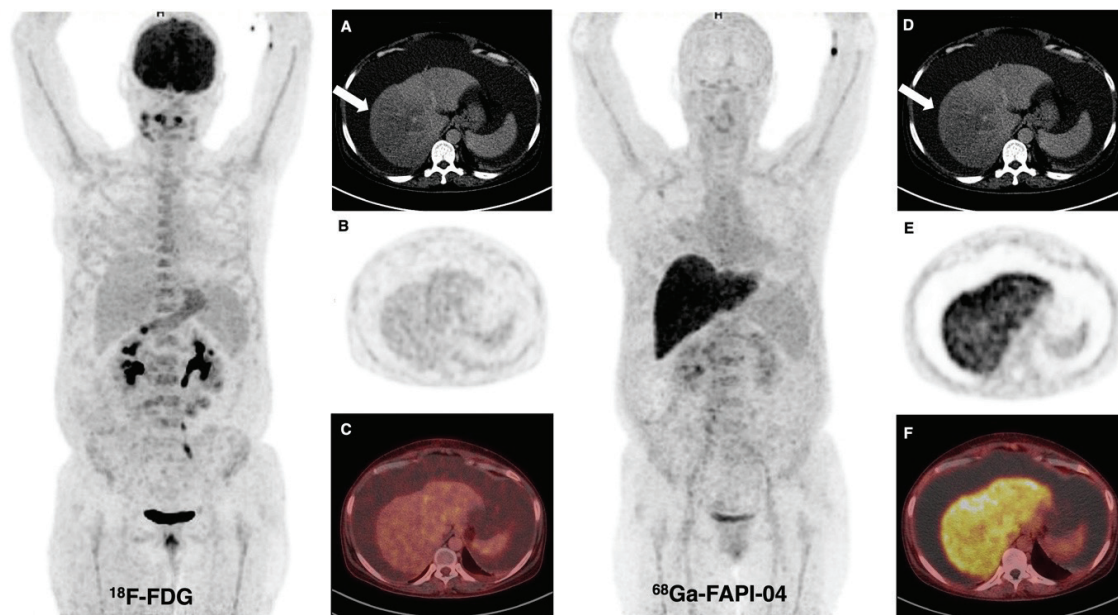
A 50-year-old woman patient presented with abdominal pain and was found to have massive ascites and had undergone ^{18}F -fluorodeoxyglucose (FDG) and ^{68}Ga -fibroblast activation protein inhibitor (FAP)-04 positron emission tomography/computed tomography (PET/CT) imaging for a suspected gastric tumor. Abnormal liver activity was not observed on ^{18}F -FDG PET/CT, but diffuse intense FAPI uptake [maximum standardized uptake value (SUV_{max}): 11.2] was seen in the liver on ^{68}Ga -FAP-04 PET/CT. The hypodense area detected in CT sections [(A, D) arrow] at the right lobe of the liver did not show prominent ^{18}F -FDG [(B) PET, (C) fusion images] or FAPI uptake [(E) PET, (F) fusion images] in the parenchyma. Also, no malignant cells were found in the peritoneal aspiration fluid. The patient is being followed up with the diagnosis of decompensated alcoholic cirrhosis.
